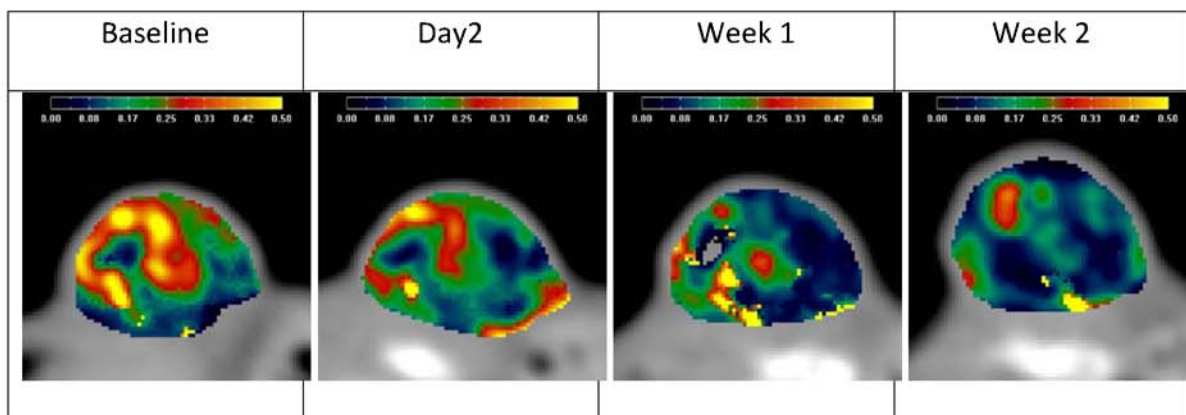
3D in vivo parametric tumor perfusion map using DCE-CT
